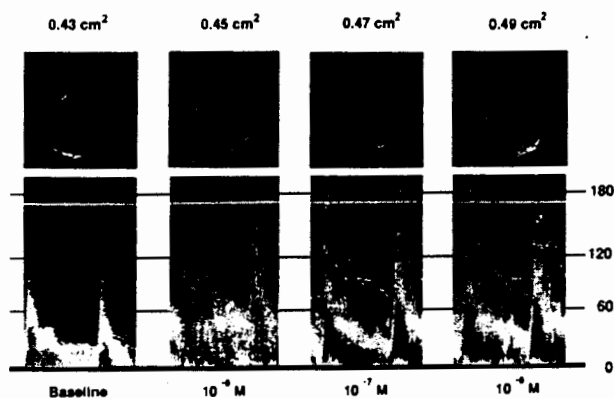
Renal artery cross-sectional area (top) and Doppler flow velocity (m/s) (bottom) at baseline and during infusion of graded doses of acetylcholine into the renal artery in one of the study patients. Reported values of cross-sectional area are averages of 15 to 30 beats.
